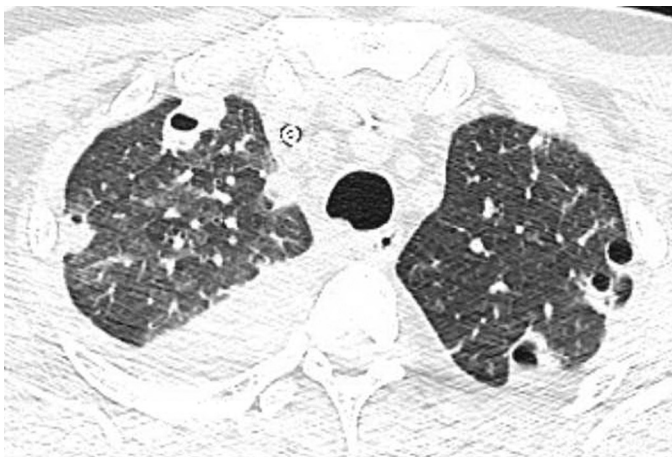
■ Axial computed tomography (CT) slice. Multiple bilateral peripheral cavitary nodules due to septic emboli.
